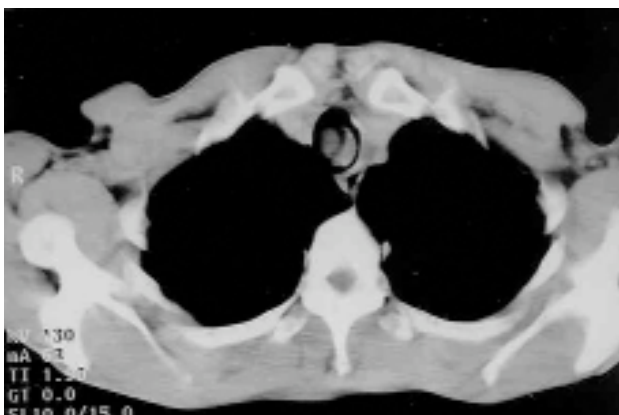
Preoperative computed tomographic view of the tumor.
